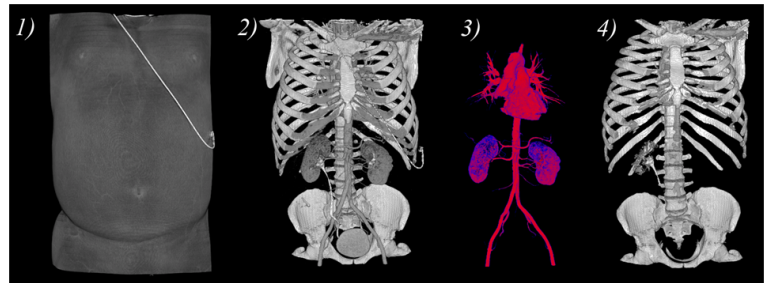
3D reconstruction of the results from the application of the realized algorithm on CTA scan of the body: 1) Body; 2) Bone and Circulatory System segmentation; 3) Circulatory System and kidneys segmentation; 4) Bone Segmentation
